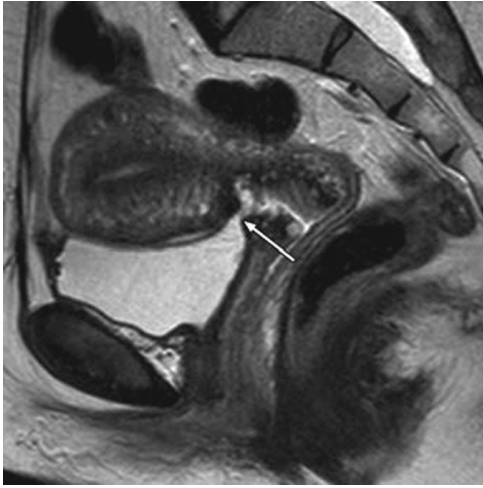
34-year-old woman 10 months after cesarean delivery with recurrent lower urinary tract infections, involuntary loss of urine, and dyspareunia. Sagittal T2-weighted 1.5-T image with pelvic coil shows vesicocervical-vaginal fistula (arrow) as high-signal-intensity linear structure connecting bladder lumen with cervical lumen.
